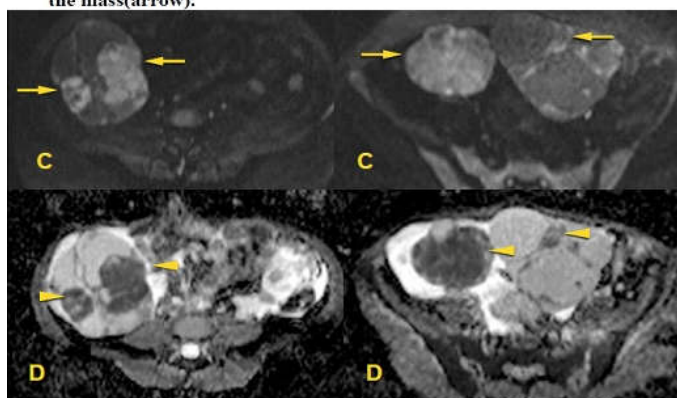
Figure Bilateral Cystadenocarcinomas.(A)DWI and (B) ADC images of bilateral adnexal masses showing multiple areas of restricted diffusion (arrows) with corresponding ADC drop (arrowheads) in the solid components of the masses. This is indicative of densely cellular tissue . Part of the lesions show facilitated diffusion.
